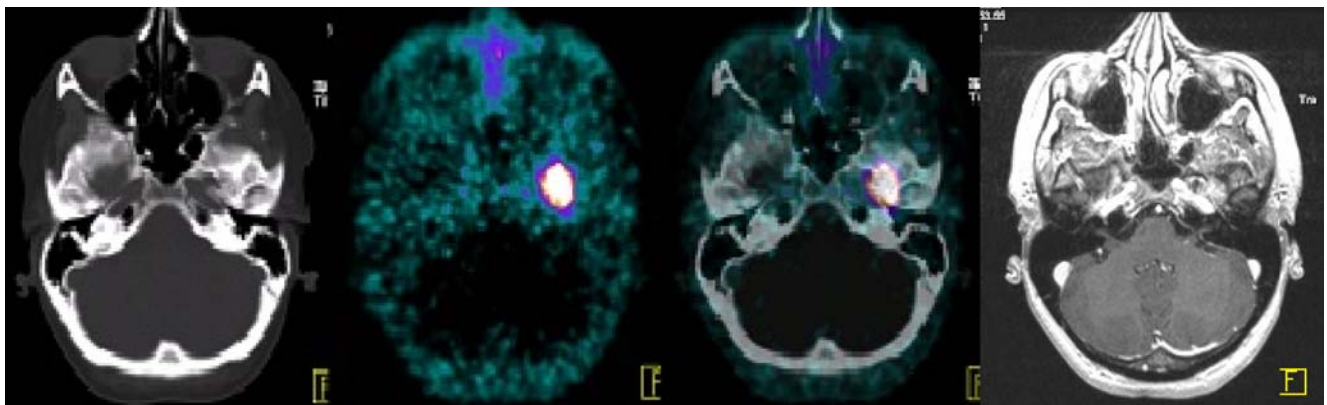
A 36-year-old female patient (pat. No. 38) with a meningioma located at the base of the skull (left sphenoid bone): ^{68}Ga -DOTATOC-PET allows markedly better tumour delineation than CT and MRI
